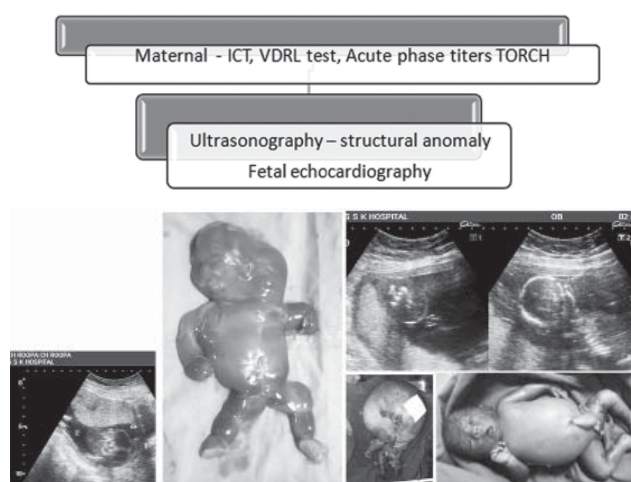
the ultrasound and postnatal picture of cystic hygroma and hydrops (left), twin reverse arterial perfusion (TRAP) with hydrops (right)
